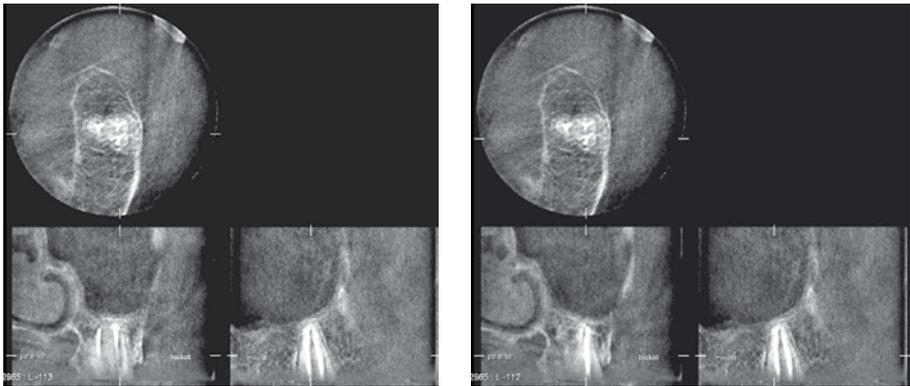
Intra-oral radiograph of the left side of the upper jaw. A radiolucent (dark) area can be seen around the root tips of the root-filled molar tooth. The question is whether the area depicted is a normal extension of the maxillary sinus or periapical bone destruction. CBCT images (below) show normal bone structure at the root apices. The radiolucent area is a normal extension of the maxillary sinus.
